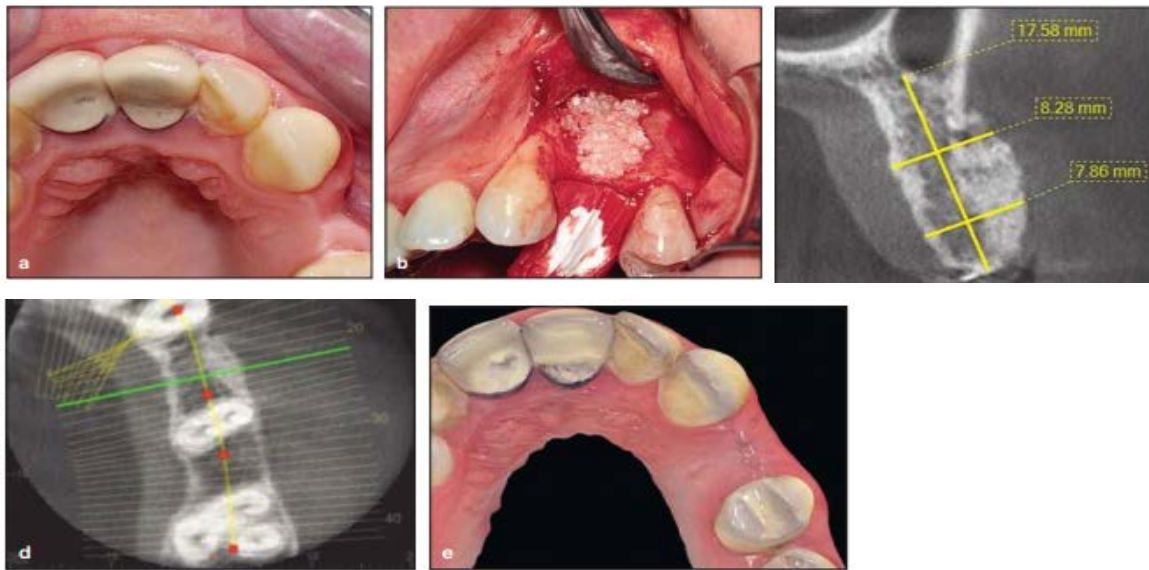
(a) An esthetic defect 12 months after extraction of the maxillary left first premolar. The maxillary left third molar was extracted, and particulate dentin was prepared utilizing the SDG procedure. (b) The buccal and occlusal alveolar ridge was exposed, and the dentin particulate graft was placed to restore the defect. (c and d) Cone beam computed tomography images showing the graft in place. (e) Three months later, a restored alveolar ridge was observed with better esthetic and functional appearance. The prosthetic restoration could then be performed with a dental implant. (Case performed by Dr Mariusz Duda.)
